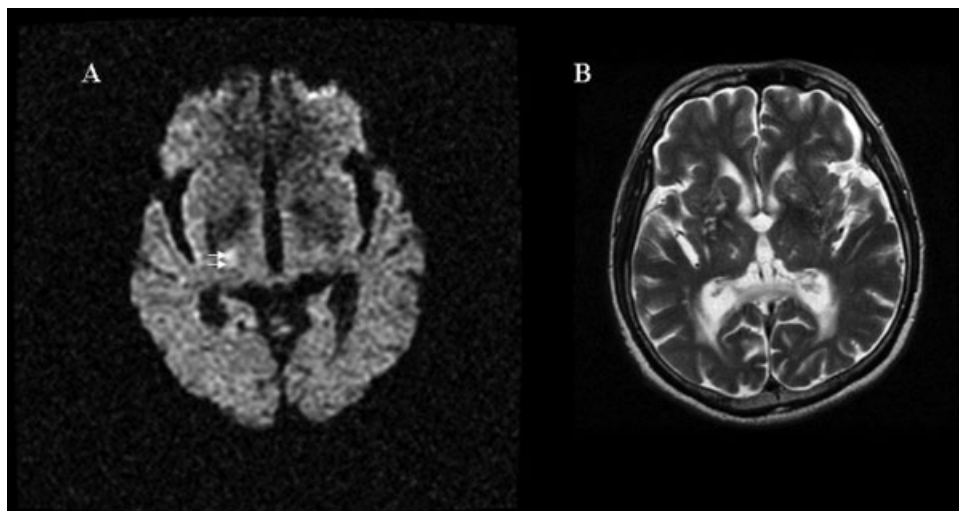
(A) Initial diffusion-weighted brain magnetic resonance imaging (MRI) scan obtained 14 days after the onset of symptoms. Note the two contiguous lesions with different high signal intensities in the posterolateral part of the right thalamus (arrows). (B) T2-weighted brain MRI showing multiple old ischemic lesions in the bilateral thalami and basal ganglia.
